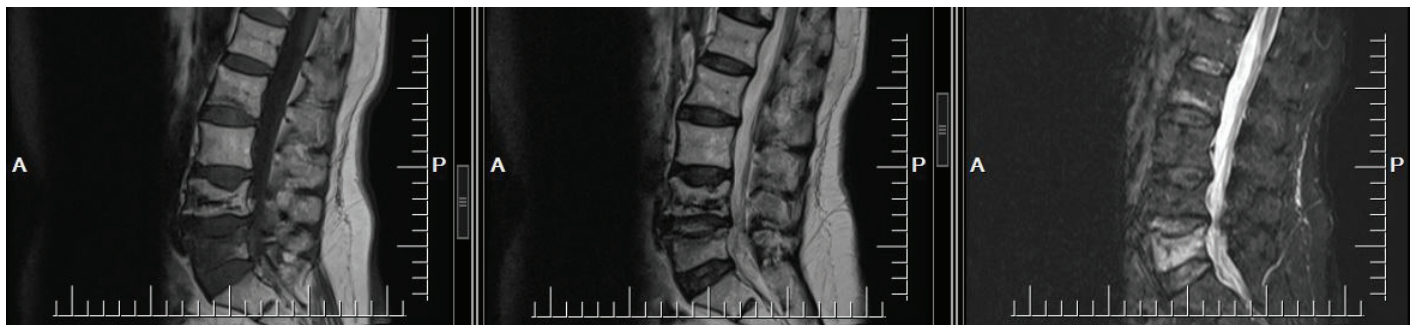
T1-weighted, T2-weighted, and fat suppression sagittal magnetic resonance imaging show the involvement, compression, and edema of the vertebral body at L2/L5 levels
